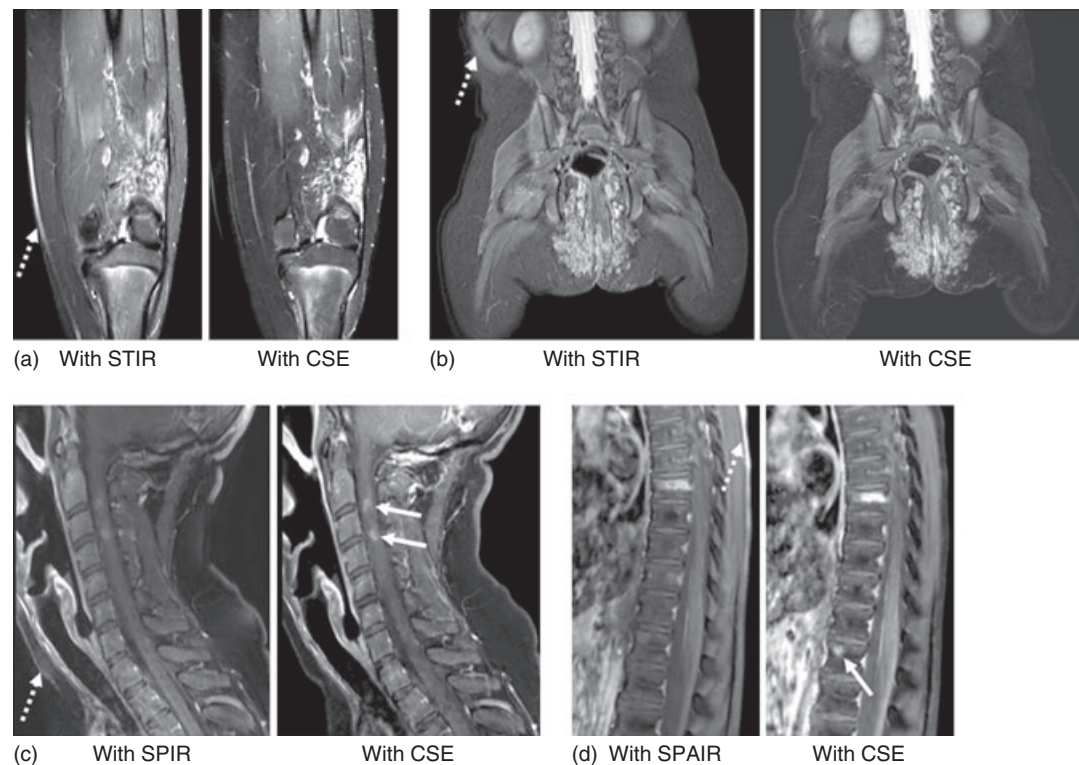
Clinical examples of the utility of CSE fat-suppression MRI protocols in improving lesion conspicuity. Comparisons are made between CSE water-only reconstructed images and other fat-suppression techniques. In (a) and (b), improved lesion conspicuity of the vascular malformation and hemangioma is observed with reconstructed water-only images from CSE MRI than with traditional T_1 -based short-TI inversion recovery (STIR) techniques, respectively. In (b), superior fat suppression with CSE is evident. In (c) and (d), lesions within the spinal cord and vertebral bone marrow are significantly better visualized with CSE MRI (solid arrows). Dotted arrows point to regions of fat-suppression failure. All images were acquired on a 3 T Ingenia platform from Philips Healthcare. (Courtesy of Smita Bailey, M.D., Deepa Biyyam, M.D., Craig Barnes, M.D., Patricia Cornejo, M.D., Scott Jorgensen, M.D., Mittun Patel, M.D., Jeffrey Miller, M.D., and Amber Pokorney, R.T., Phoenix Children's Hospital)
